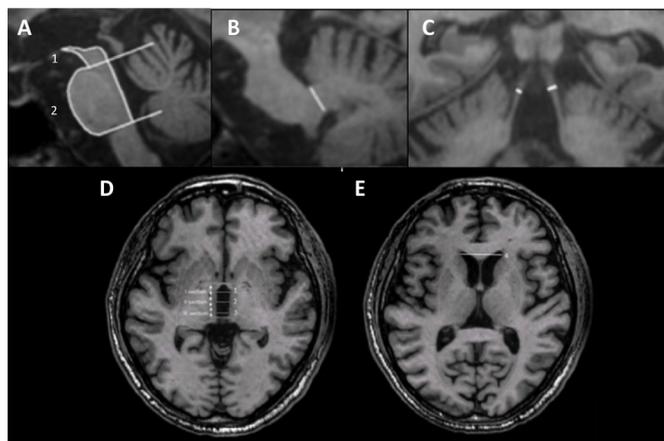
Midbrain MRI assessments included mid-sagittal midbrain (A1) and pons area (A2), middle cerebellar peduncles (B) to superior cerebellar peduncles (C) ratio (MCP/SCP), the pons area (A2) to midbrain area (A1) ratio (P/M), the MR Parkinsonism Index (MRPI) = (P/M) × (MCP/SCP), the P/M 2.0 = (P/M) × (third ventricle width (D)/frontal horns width (E)), and the MRPI 2.0 = MRPI × (third ventricle width (D)/frontal horns width (E)). Images (A), (B) and (C) are modified from ref²; images (D) and (E) are modified from ref⁹.
